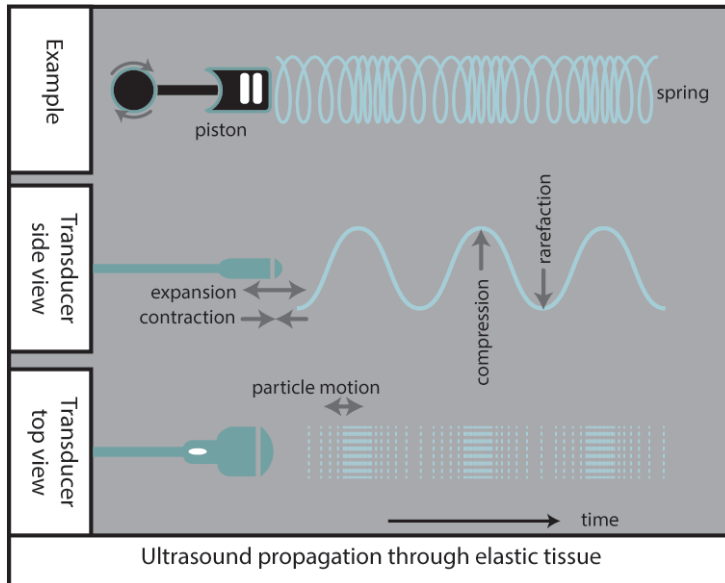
ultrasound propagation through elastic tissue, compared to a piston attached to a spring. High-frequency expansion and contraction of piezoelectric elements generate ultrasound, which propagates as a longitudinal wave through tissue by compressing and rarefaction of tissue particles. Figure adapted from Buschberg et al.¹⁸.
